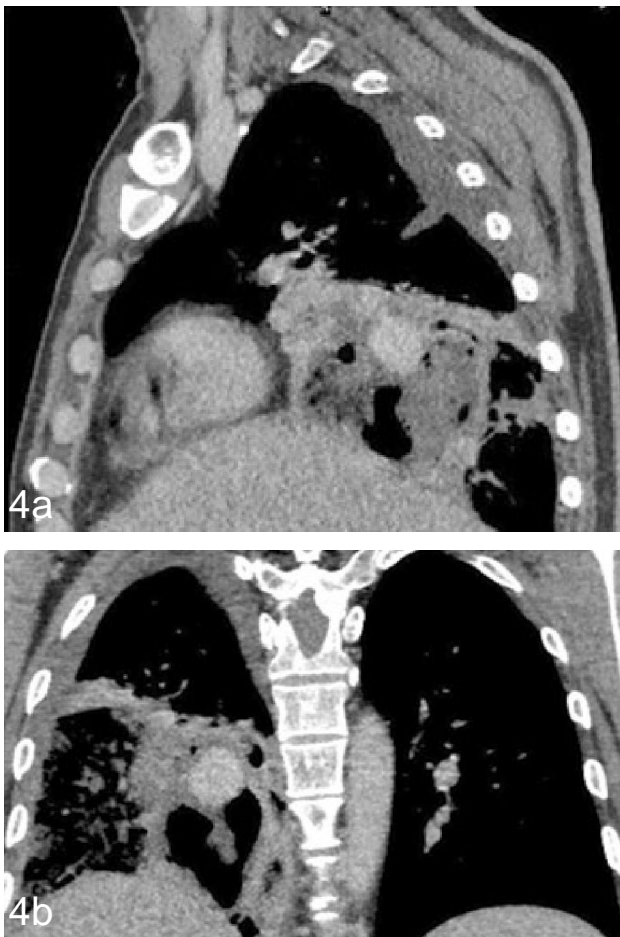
Contrast CT thorax in sagittal and coronal planes respectively showing well defined intensely enhancing lesion measuring 2 x 2.5 cm in relation to wall of fluid filled cavity in right lower lobe.
